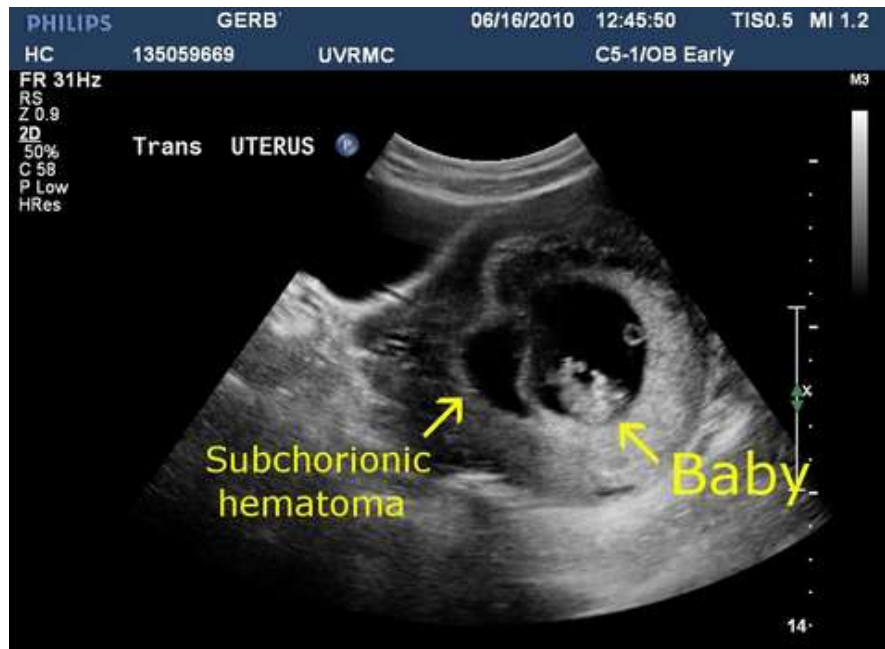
Ultrasound Showing Subchorionic Haemorrhage in Early Pregnancy, A Key Risk Factor for Miscarriage And Other Complications.
